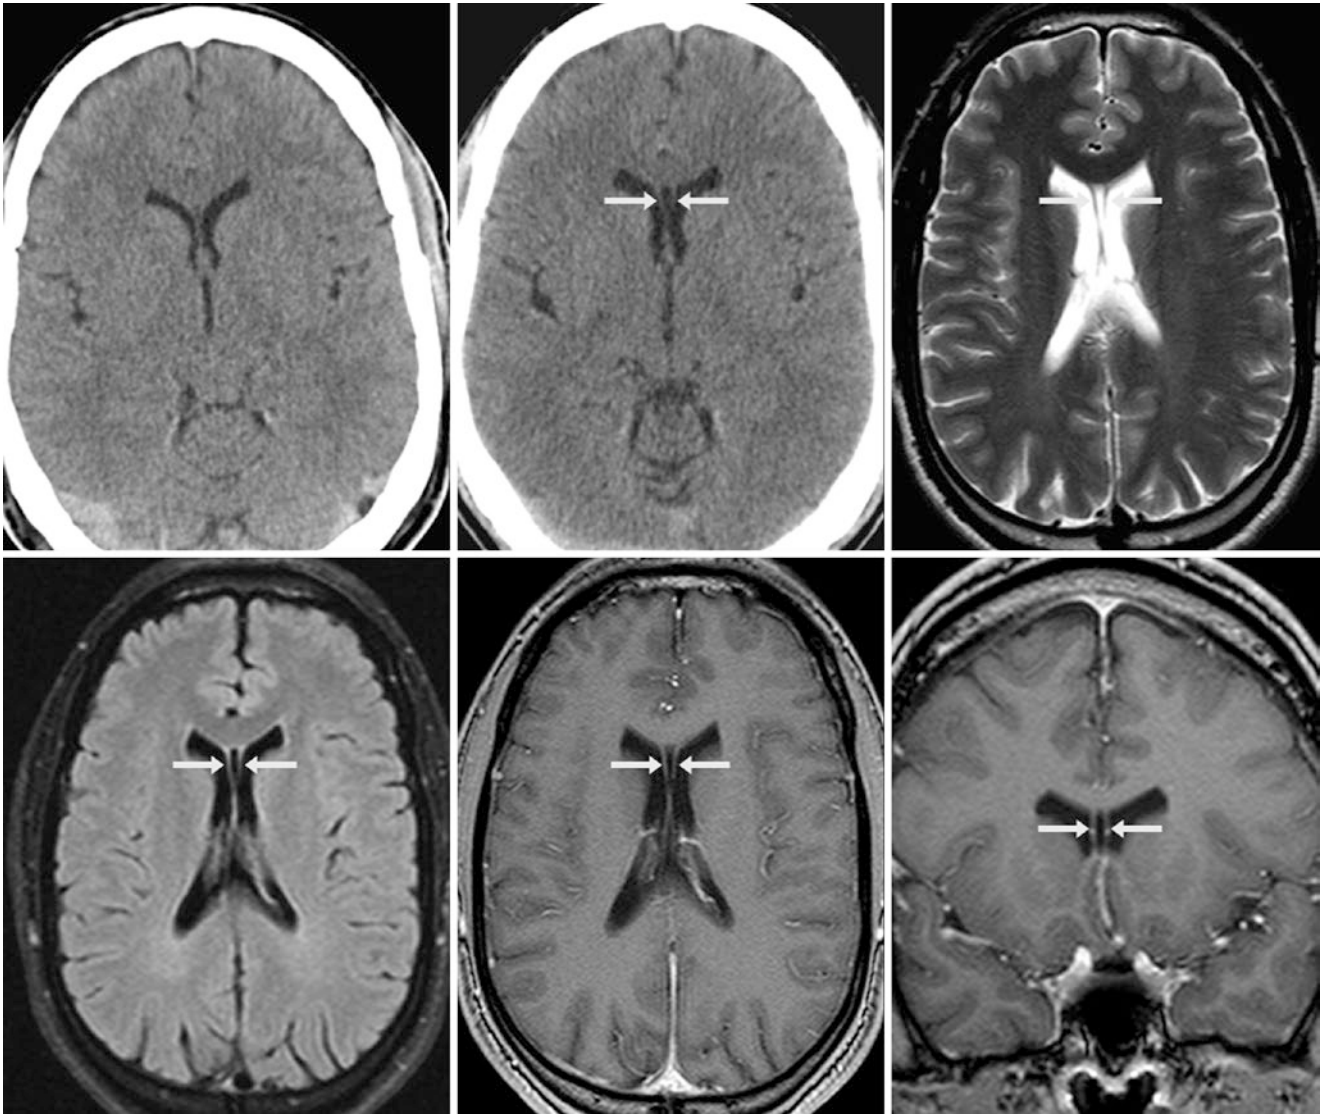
A 35 year old with a CSP that is present but poorly seen on a 7-mm thickness NECT (*left*). A 2-mm thickness NECT 8 years earlier (*middle*) better demonstrates the CSP. This is only present anteriorly, as seen on axial T2WI (*top right*), FLAIR (*bottom left*), and axial (*bottom middle*) and coronal (*bottom right*) postcontrast T1WIs
